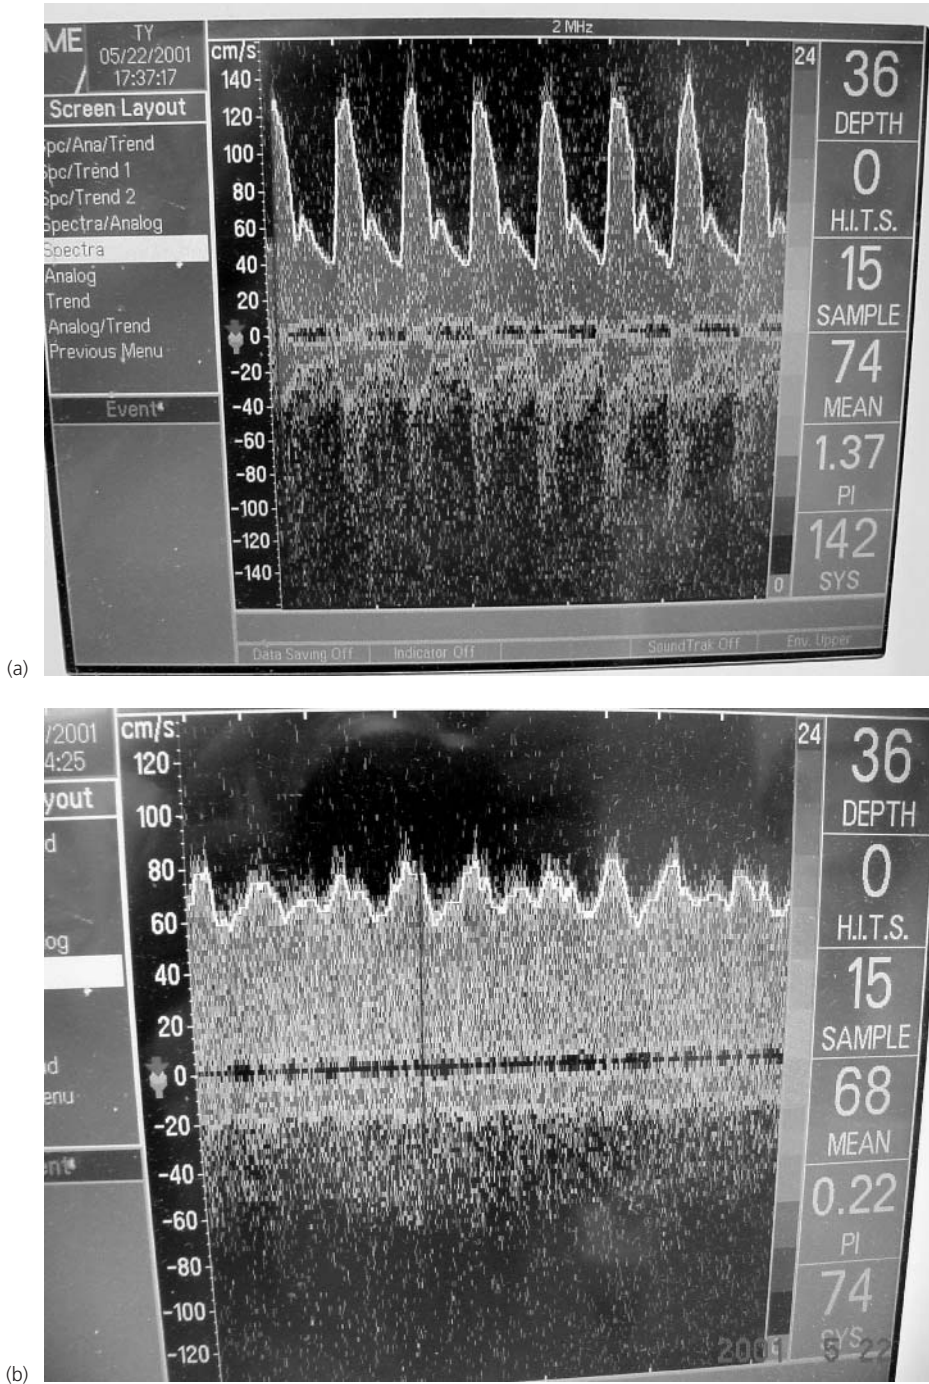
Transcranial Doppler ultrasound monitor display. A velocity spectrum is displayed with numerical readouts for peak and mean cerebral blood flow velocity (CBFV) in centimeters/second and pulsatility index, as well as depth of insonation and sample volume length. (a) Cerebral blood flow velocity spectrum before bypass, (b) on bypass with non-pulsatile flow, and (c) two cerebral emboli can be seen as high intensity signals against the background CBFV spectrum.
